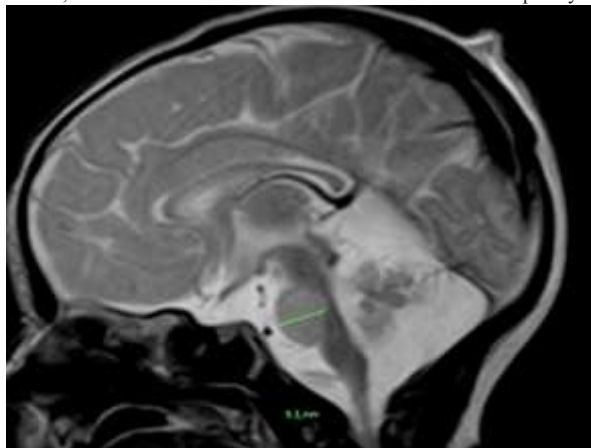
T2-weighted axial MRI showing severe pontocerebellar hypoplasia and corpus callosum thinning
